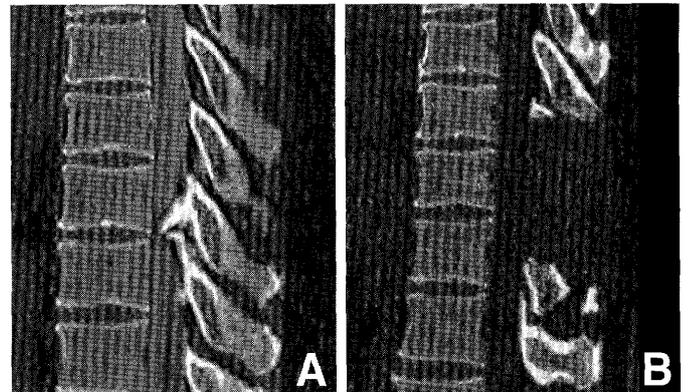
A: Sagittal computed tomography scan of the spine showing ossification of the ligamentum flavum (OLF) at the T9-T10 levels. B: Postoperative computed tomography scan demonstrating the T9-T10 laminectomy and resection of the OLF.
